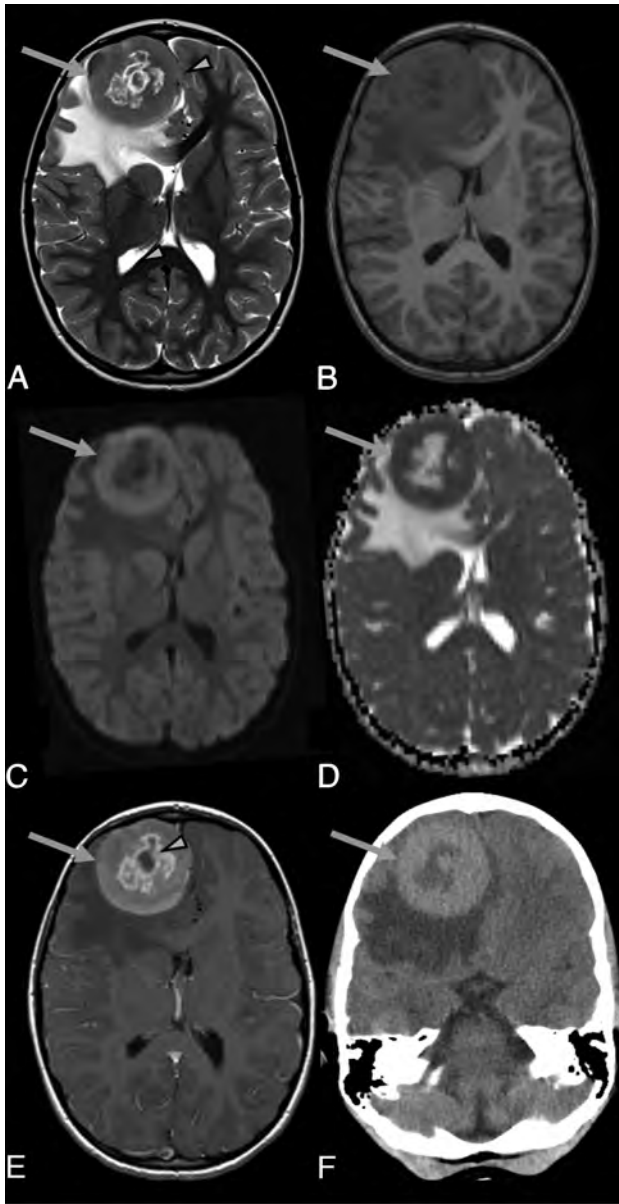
Brain images of a 6-year-old girl with pathology-proven unifocal JXG who presented with increased frequency of headaches, occasionally accompanied by vomiting. Brain MR imaging with an axial T2-weighted image (A), axial T1-weighted image (B), axial DWI (C), axial ADC map (D), axial T1+CE-weighted image (E), and axial noncontrast CT (F) shows a large, round, unifocal mass lesion located in the right frontal lobe (arrows in A–F) with central necrosis (arrowhead in E), perilesional edema, and right-to-left midline shift (arrowhead in A). Compared with cortical GM, the solid non-necrotic peripheral component of the lesion is T2-isointense (A) and T1-isointense (B) and shows contrast enhancement (E) and restricted diffusion (C and D). The axial CT image (F) demonstrates the hyperdense (solid portion), large mass lesion.
